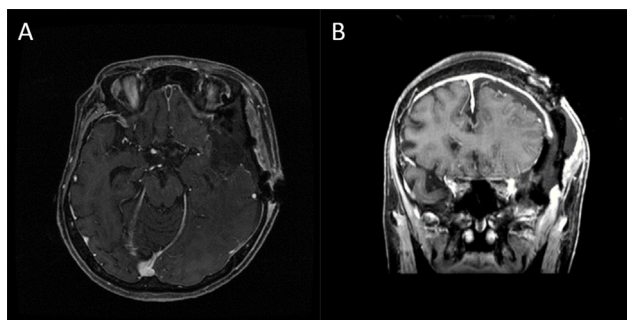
Postoperative magnetic resonance imaging (A, axial section; B, coronal section). The gadolinium-enhanced T1-weighted image shows tumor resolution. Total resection is confirmed.
